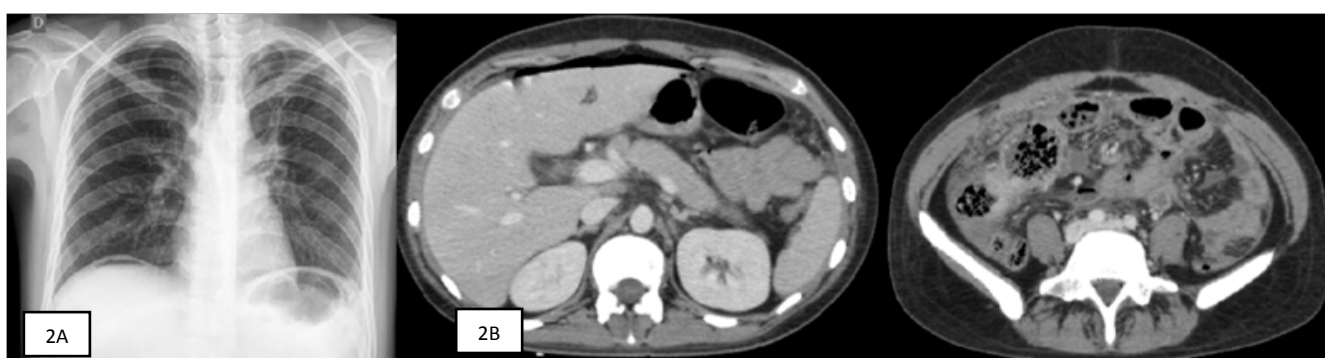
(A) Chest X-ray: Shows pneumoperitoneum (thin arrow) and improvement of lungs infiltrates. (Thick arrow). (B) Abdomen and Pelvis CT SCAN: Shows pneumoperitoneum (thin arrow), moderate ascites and cecal thickening (Thick arrow).
